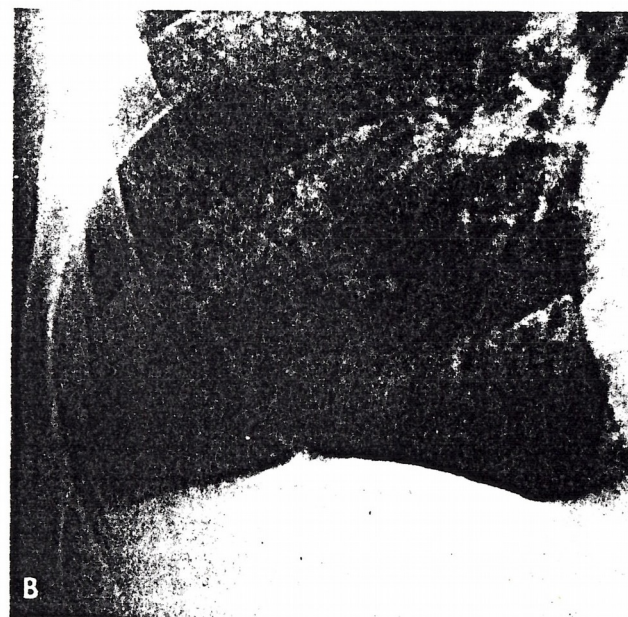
Radiograph of insulation worker who presented with breathlessness, finger clubbing, and evidence of cor pulmonale, showing advanced asbestos fibrosis, obliterated costophrenic angles, and calcification over right hemidiaphragm.
